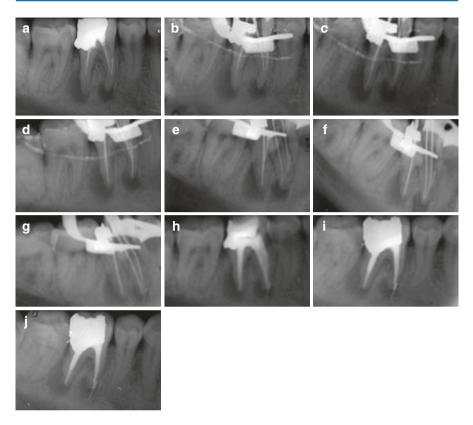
(a) Preoperative radiograph. An approximately 4 mm long fragment of an SS file can be seen in the mesial root of an underobturated mandibular molar. (\mathbf{b} -g) "Movement" of the fragment toward the apex and eventual extrusion into the periapex during efforts to bypass and retrieve it with the file bypass technique. (\mathbf{h}) Immediate post-obturation radiograph. (\mathbf{i}) One-year recall radiograph (Courtesy Dr. G. Alexandrou)
